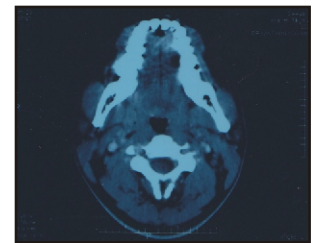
CT scan showing axial section of the pharyngeal airway
